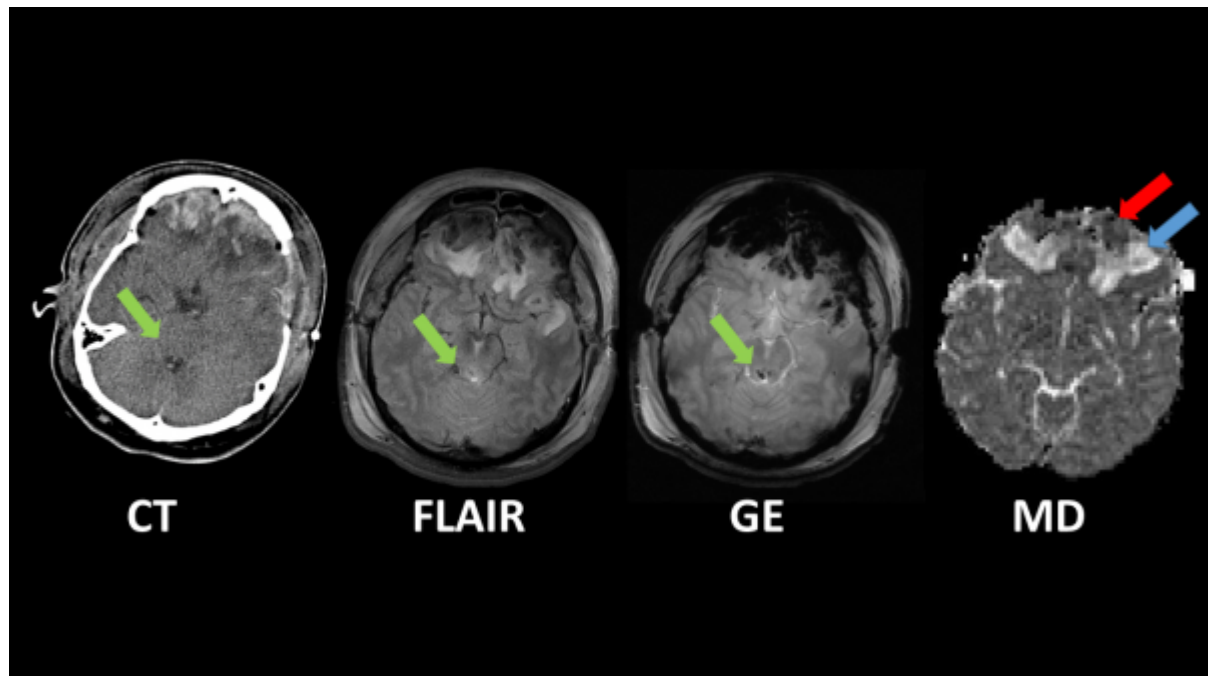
Detection of brain stem lesions and contusions after TBI with CT and MRI. Bifrontal contusions can be seen on CT and all MRI sequences. The MD (mean diffusivity) map calculated using DTI shows a bright area (blue arrow) before a darker contusion core (red arrow). The bright area represents an area of vasogenic oedema. A small lesion can be seen on the posterior brainstem in the region of the fourth ventricle (green arrow), which is most conspicuous on the GRE sequence (sensitised to blood products). The brainstem lesion is not able to be seen on the CT scan.
